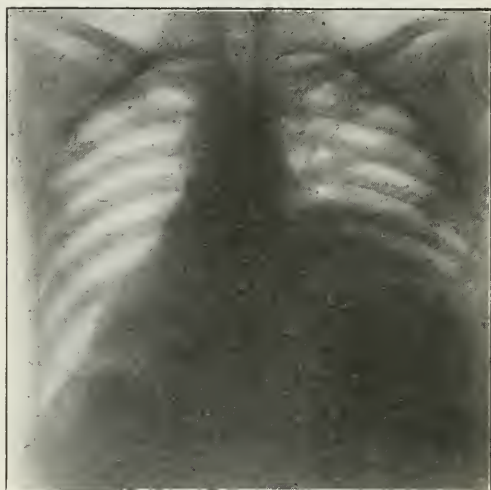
Case X. Roentgenogram taken just before death. Note displacement of right diaphragm with compression of right lung and displacement of heart upward. Aorta dilated.
